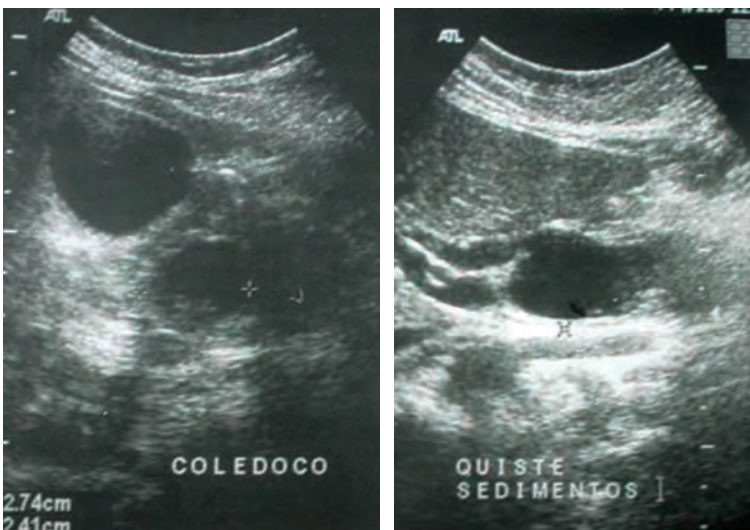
Another ultrasonographic study taken as outpatient showing a normal liver and anechoic gallbladder, measuring approximately 6.3×3.1 cm, with a 4 mm wall and the presence of a common bile duct cyst in the distal region measuring $1.35 \times 2.4 \times 0.72$ cm.
